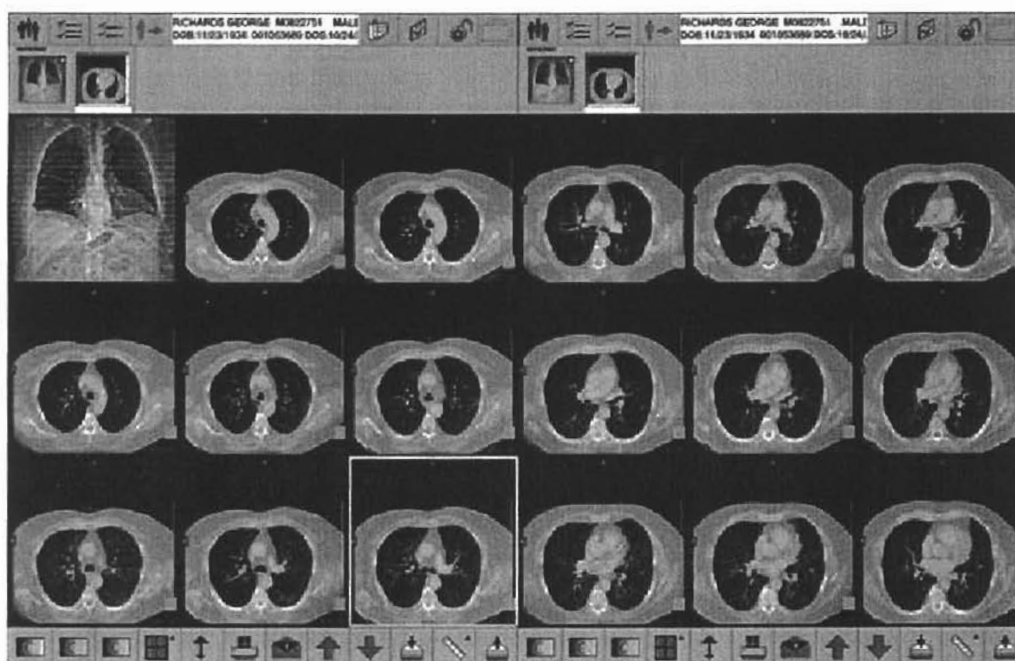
Example of a picture archiving and communication systems diagnostic workstation displaying a computed radiography chest examination.
